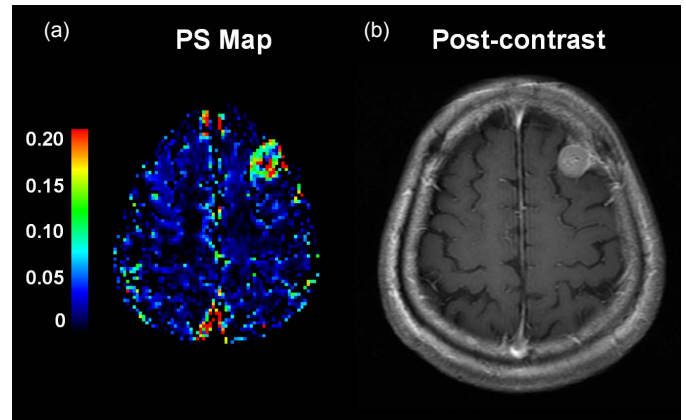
The PS map (a) and T1-weighted image (b).
